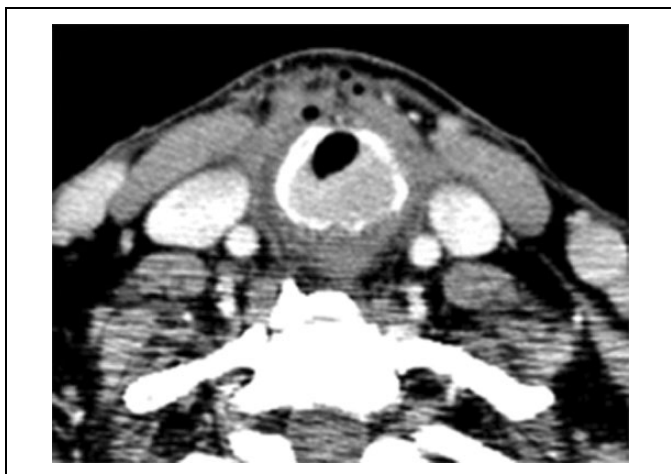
Computed tomography (CT) scan showed a cricoid cartilage mass 2.4×1.6 cm with destruction of cartilage, causing significant airway stenosis.
